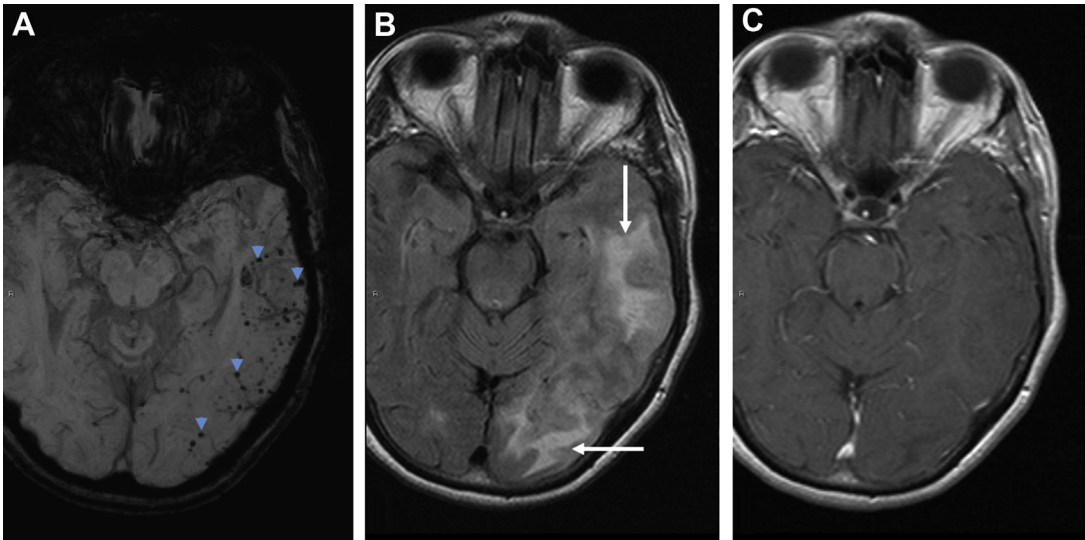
CAA-related inflammation. Axial SWI (A), axial FLAIR (B), and axial postcontrast T1-weighted (C) MR images in a 66 year old with altered mental status. SWI demonstrates numerous parenchymal microhemorrhages as low signal intensity foci in a peripheral lobar distribution (blue arrowheads in A), which corresponds to the large area of temporo-occipital vasogenic edema noted on FLAIR images (white arrows in B). Minimal if any regional leptomeningeal enhancement is present on postcontrast imaging.
